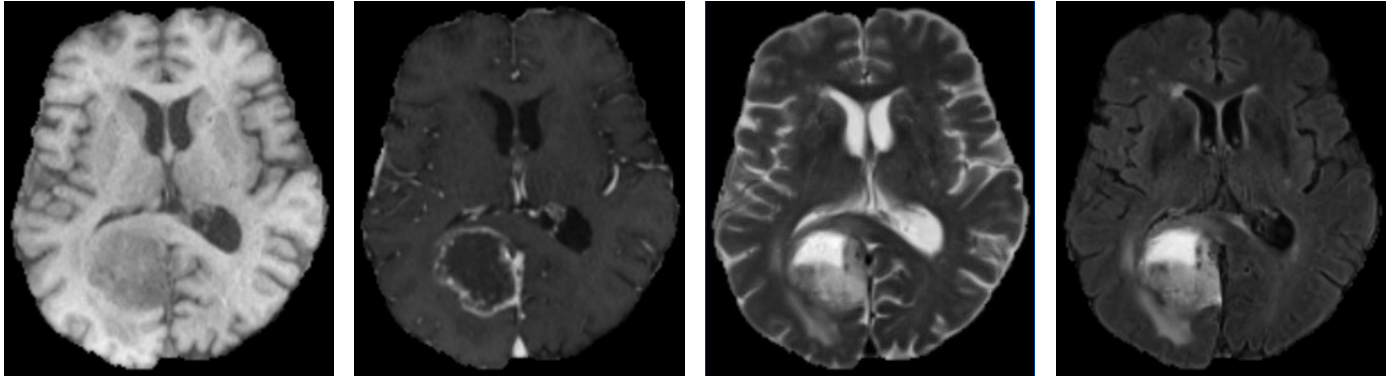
Examples of different MRI imaging modalities. From left to right: T1, T1ce, T2, and FLAIR.
